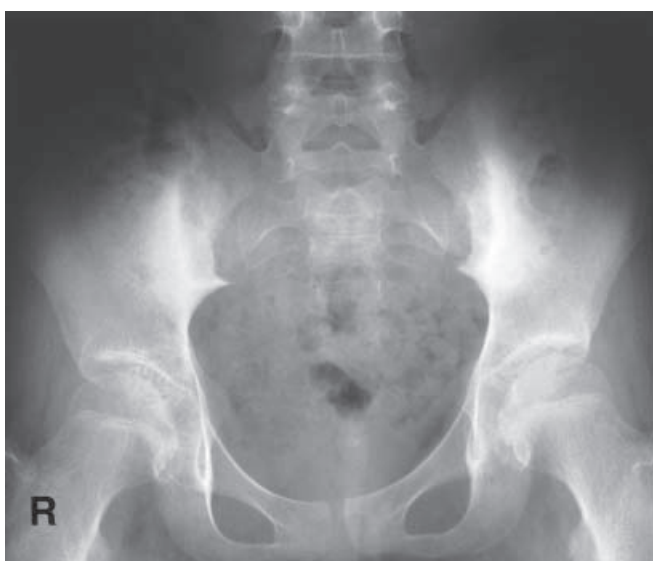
Radiograph taken in 1999 (11 years of age), showing bilateral grade 3 sacroiliitis
